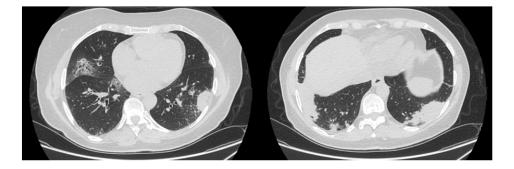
Pulmonary involvement: computed tomography images performed in December 2020 before bronchoscopy
